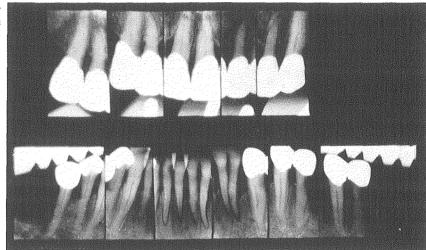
Roentgenograms taken 7 years after the construction of partial dentures.
